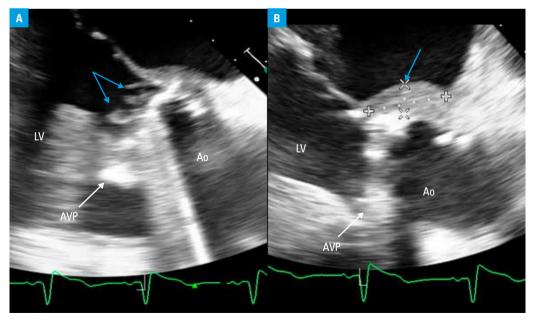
Echocardiographic imaging of prosthetic aortic endocarditis; A – bacterial vegetations attached to the mechanical prosthesis (blue arrows); B – inflammatory infiltration at the level of the non–coronary sinus of Valsalva (blue arrow); TEE, long-axis view
